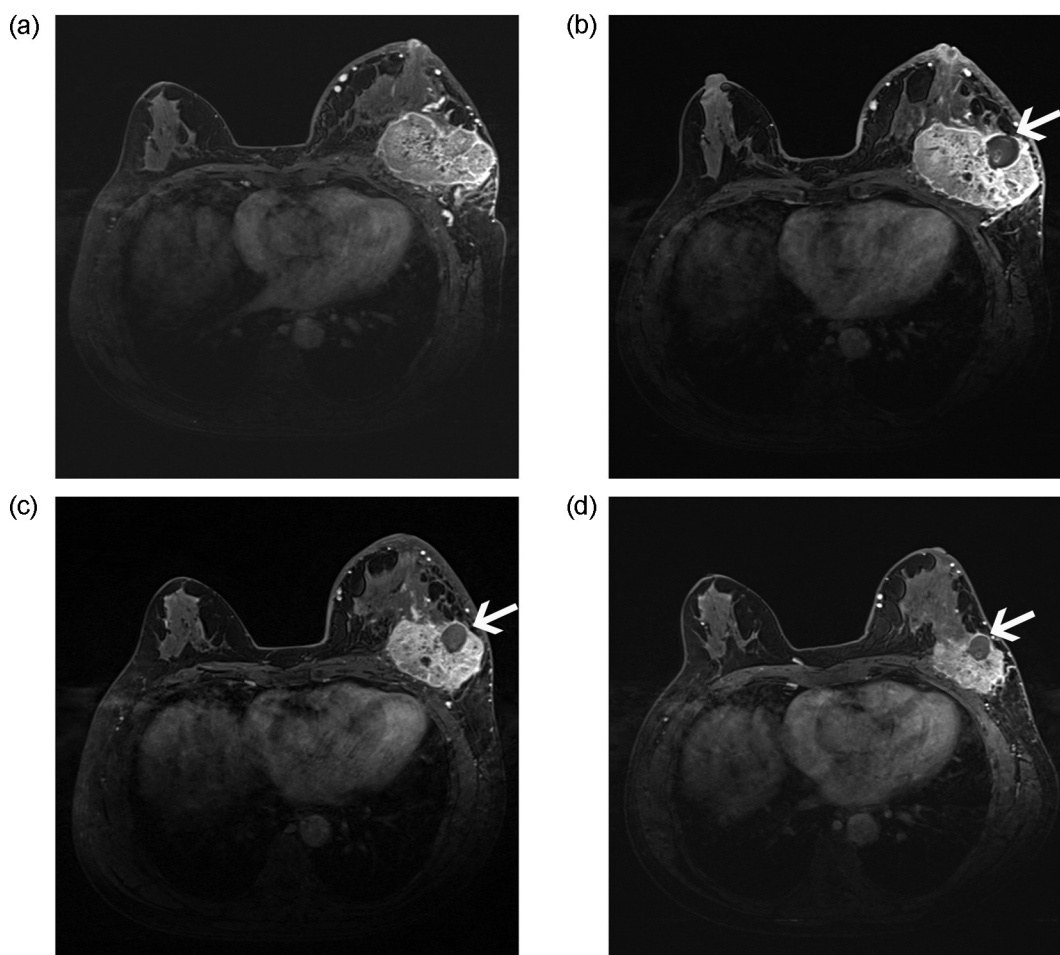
MR images acquired by the three-dimensional transverse fast low angle shot, T1-weighted sequence with fat suppression in 58-year-old woman shows the evolution of ablated breast cancer. (a) MR image before treatment. (b) MR images 24-h post-ablation shows the ablated zone (arrow) without enhancement. The margin is clear and smooth. (c) MR image 3-week post-ablation shows the ablated zone (arrow) is still clear and the diameters significantly decrease. (d) MR image before surgery shows a gradual decrease of the diameters of the ablated zone (arrow).
